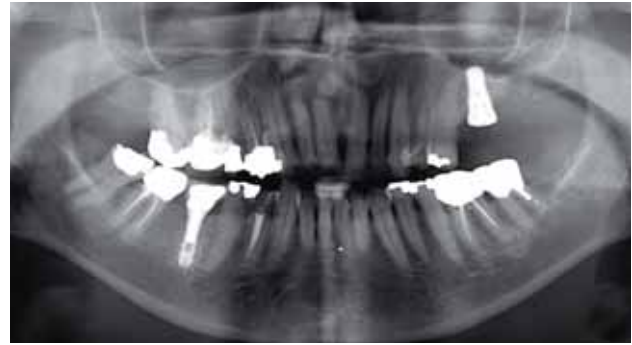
Post-operative panoramic x-ray after one dental implant was placed in the upper left quadrant taken in October 2008.
